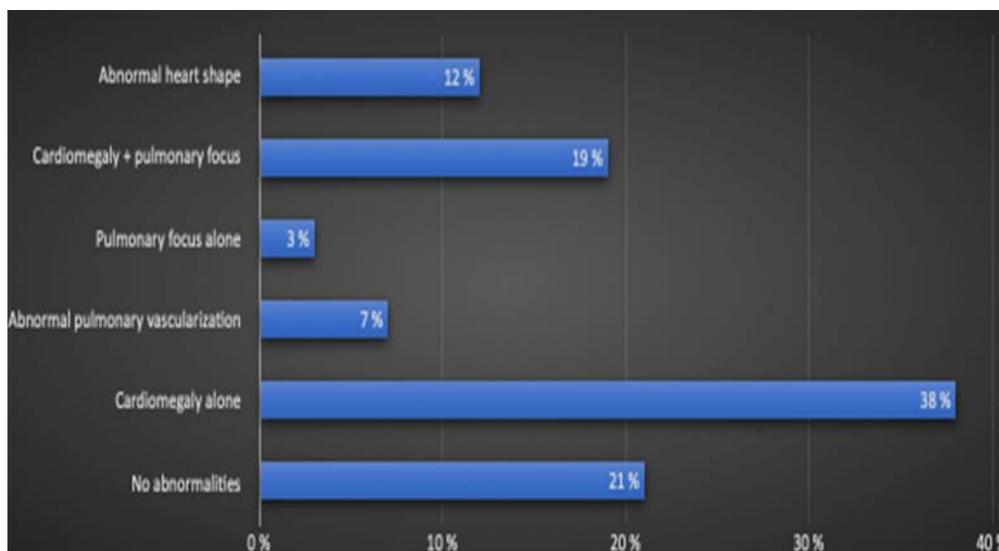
Interpretation of chest X-ray.
